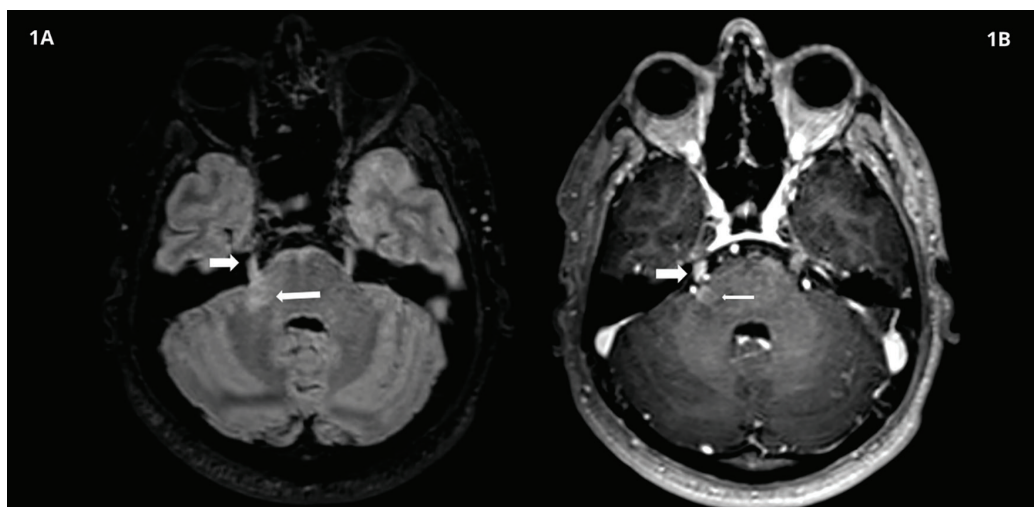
Brain MRI demonstrating trigeminal nerve involvement
